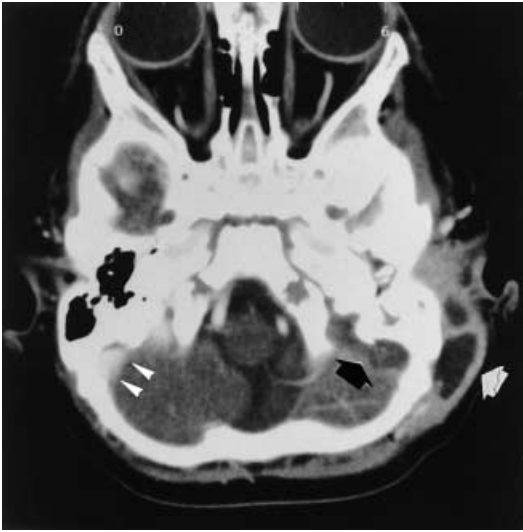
Computed tomography showing a child with left-sided mastoiditis. A lateral neck abscess (*white arrow*) developed as well as thrombosis of the left sigmoid sinus (*black arrow*). Regular enhancement of the contralateral sigmoid sinus (*arrowheads*)
